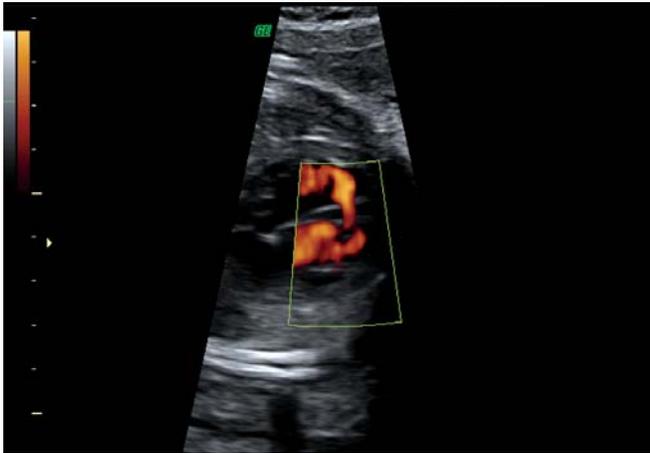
Muscular VSD in power Doppler mode
